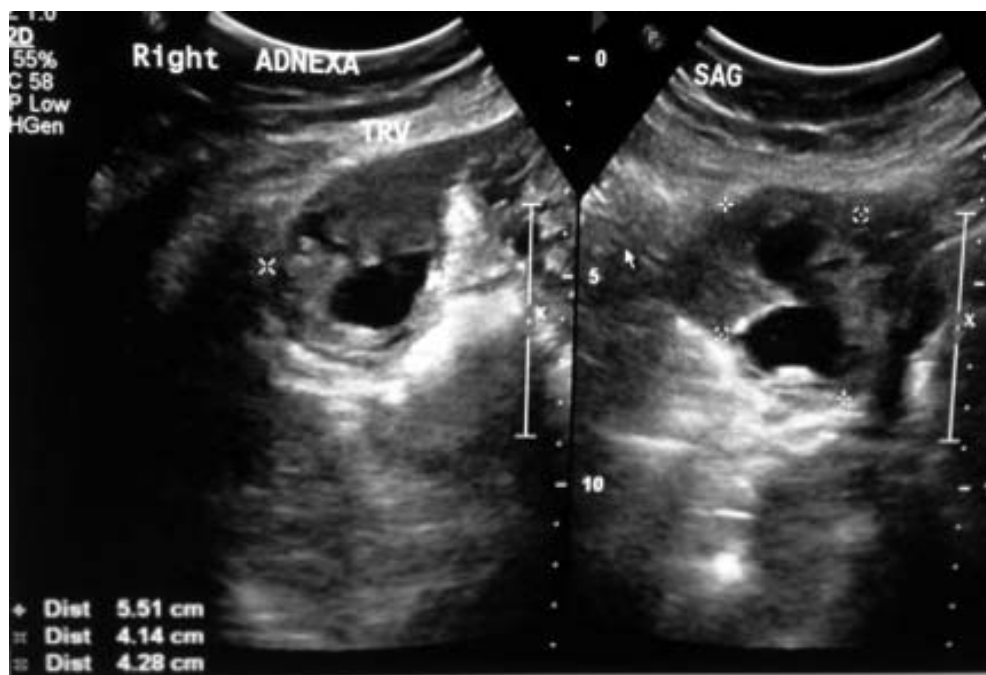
The ultrasound performed at 20 weeks' gestation shows a complex 5 cm mass in the right adnexa.
